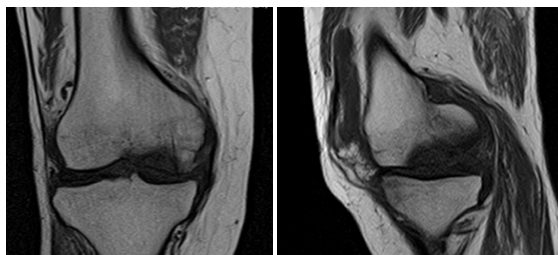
Knee MRI: Bone Infarction in the Medial Femoral Condyle.
